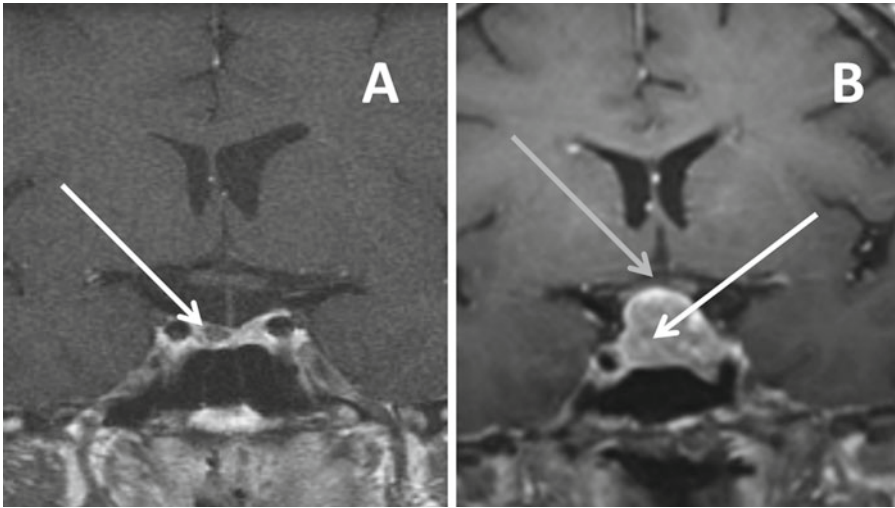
MRI T-1 weighted images in the coronal plane after gadolinium showing: (a) a pituitary microadenoma (*white arrow*) located in the right side of the gland that enhances
